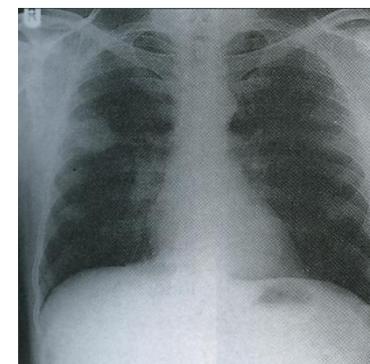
An early peripheral bronchial carcinoma in the right mid-zone, found by chance on a chest X-ray. The hilum appears normal, and this was confirmed at tomography. This patient underwent a successful and probably curative lobectomy.
